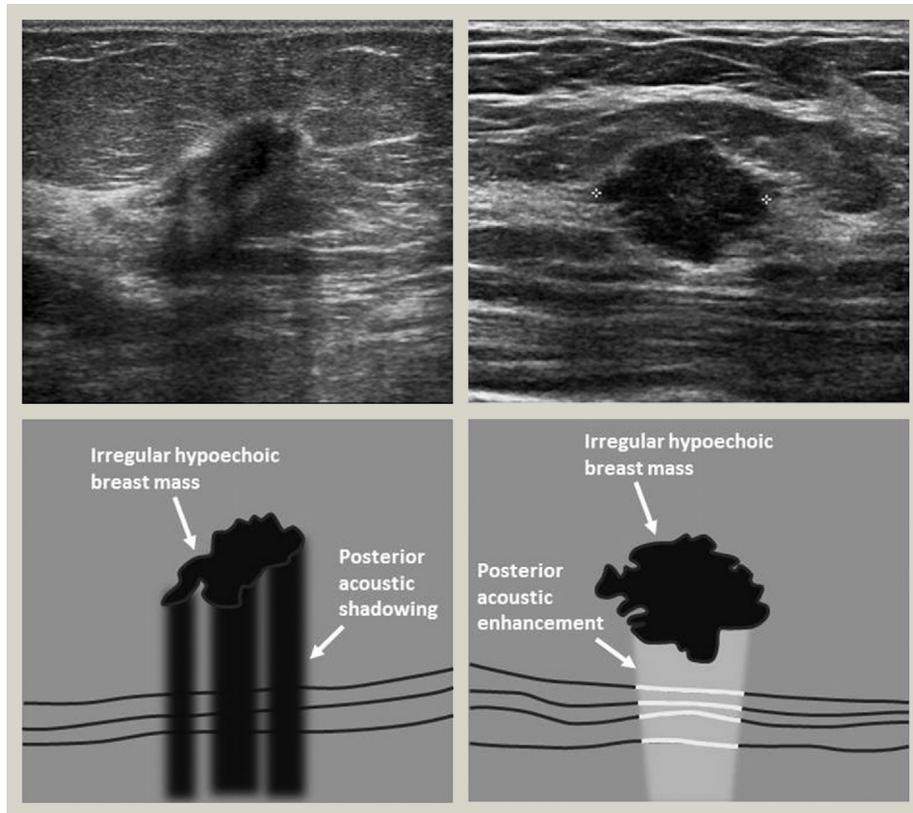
Two examples of hypoechoic masses on ultrasound. The irregular margins suggest malignancy. The image on the left shows the typical posterior acoustic shadowing (darkness deep to the mass) seen in malignant lesions. The image on the right in contrast shows posterior acoustic enhancement (brightness deep to the mass), which is a feature more typically seen in benign lesions. In both cases core biopsy confirmed grade 3 invasive ductal carcinoma.
